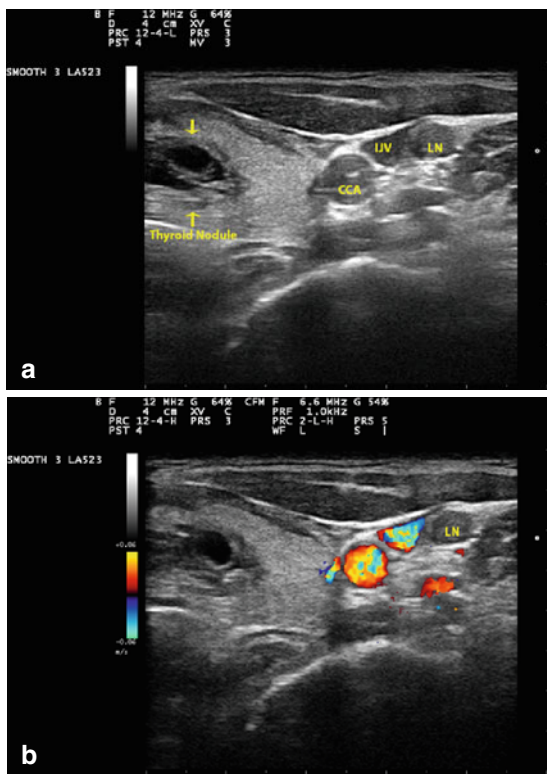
Left neck level IV. US images show a predominantly cystic complex left thyroid nodule, the common carotid artery (CCA), internal jugular vein (IJV), and a round-shaped lymph node (LN) posterior to the IJV (a). Corresponding findings by Doppler exam (b). US-guided FNA of both the thyroid nodule and lymph node showed papillary thyroid carcinoma
